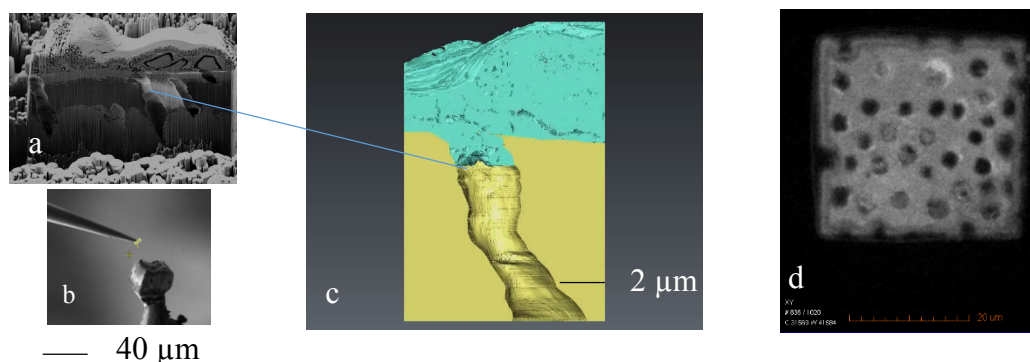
(a) FIB slice and view through a treated sample, (b) a FIB cut cube mounted on a pin for tomography (c) a reconstruction through a single tubule and (d) a plan-view from 5 μm beneath the surface from the X-ray tomography data showing the occlusion of the tubules
